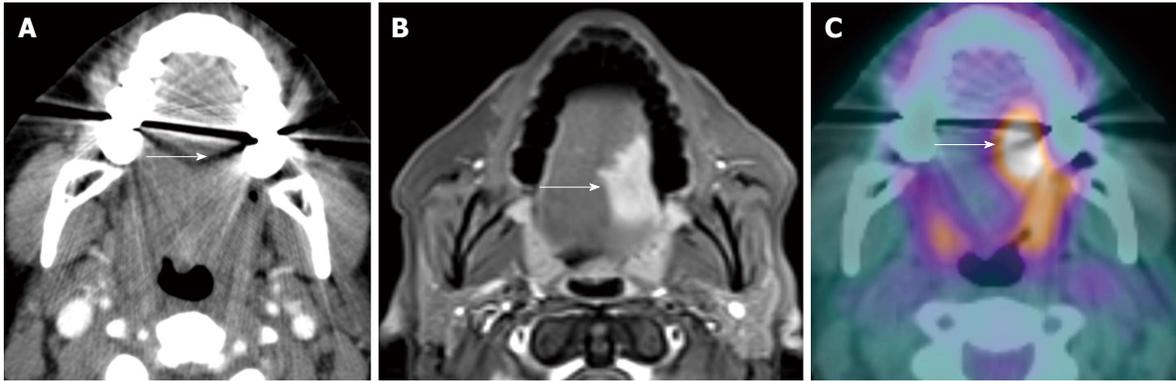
Dental amalgam artifact obscuring an oral cavity tumor. A: The T2 left lateral oral tongue squamous cell carcinoma (arrow) was obscured by the dental amalgam artifact on contrast-enhanced computed tomography (CT); B: The lesion is better evaluated on the contrast-enhanced T1W; C: Positron emission tomography/CT (PET/CT) images. Information from the PET portion is clearly less affected by streak artifact. However, PET/CT does not add additional information to magnetic resonance imaging in terms of primary oral cavity lesion extent for the majority of cases.
